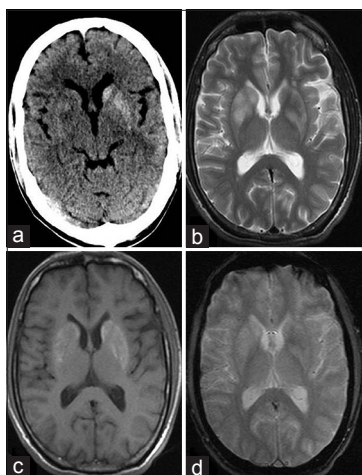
Axial plain CT scan of the brain shows bilateral hyperdense basal ganglia (left > right). (a) Axial T2- and T1-weighted MRI images; (b and c, respectively) Reveal increased signal intensity in the basal ganglia bilaterally. An area of decreased signal intensity seen in the left globus pallidus on T2W and GRE (gradient echo sequence) (d) Images corresponds to petechial hemorrhages
